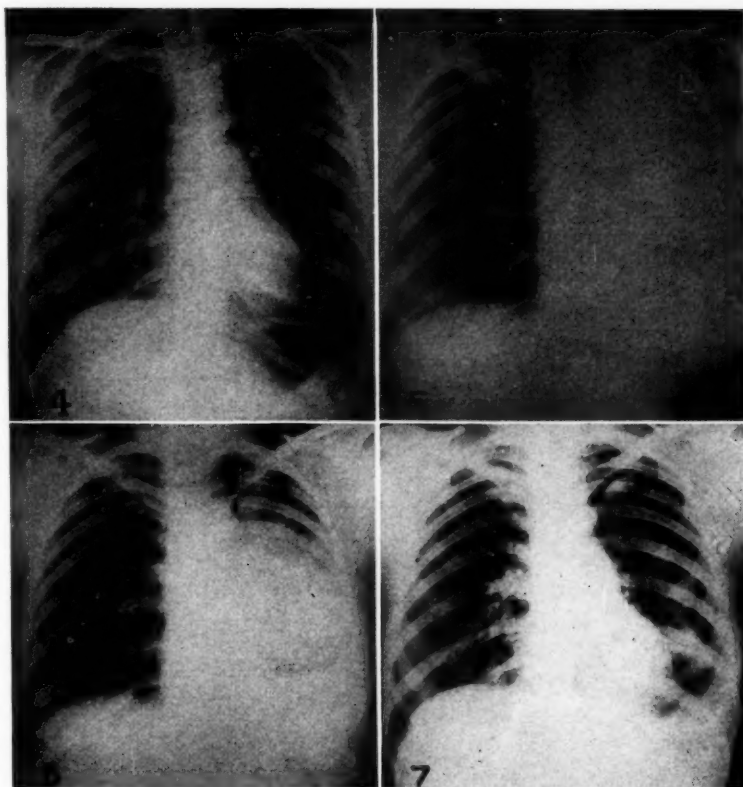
Case 3. Roentgenogram taken November 8, 1938. Note density in left hilum.
